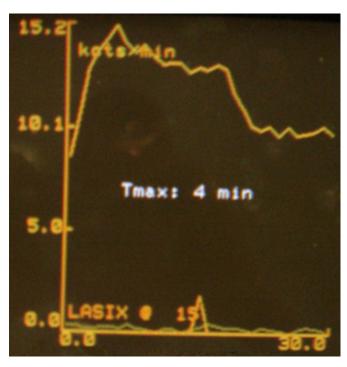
Tc -DTPA renal scintigraphy with dynamic acquisition of sequential images showed an increase in the time of collecting of the tracer and a delay of excretion.
